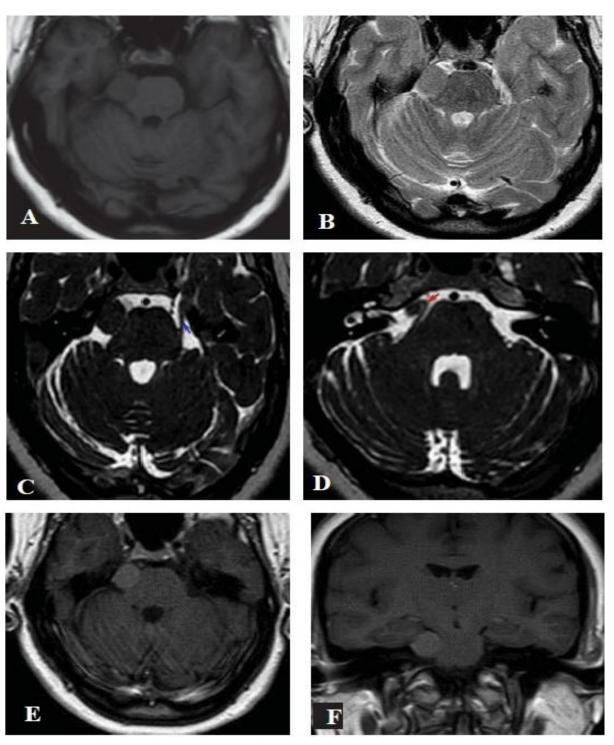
MRI brain of case no 4.
